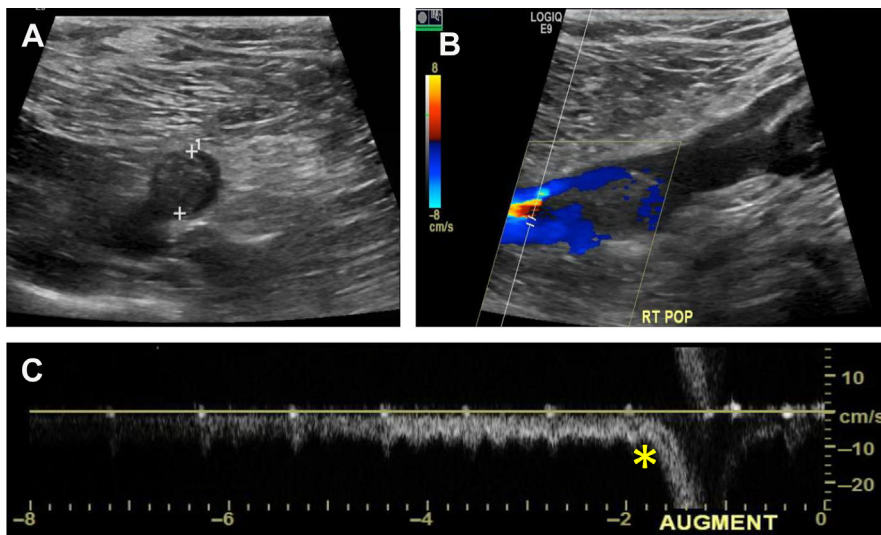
Ultrasound evidence of deep venous thrombosis at the bifurcation of the right popliteal vein. (A) Demonstration of partially occlusive thrombus in the right popliteal vein and accompanying color flow Doppler imaging (B) showing decreased flow in the right popliteal vein. Spectral waveforms measuring the velocity of flow demonstrate an increase in velocity during an augmentation (marked by the yellow star) (C), consistent with the presence of residual flow.
